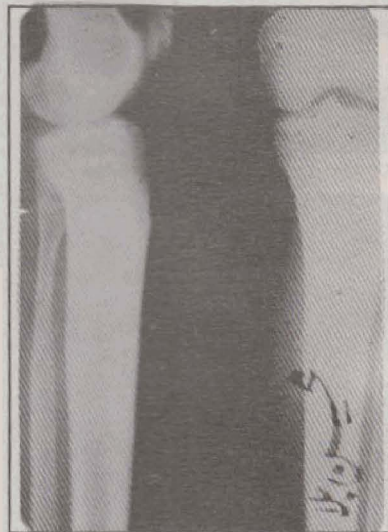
Showing Case 2 a) Pre-Operative X-rays
